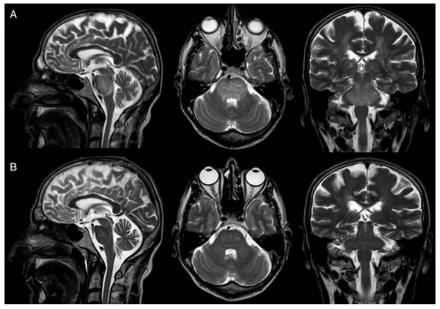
Brain MRI before and after treatment. (A) 1.5 Tesla brain MRI, before treatment. Axial, sagittal, and coronal T2-weighted images show the presence of a swollen pons with diffuse hyperintensity of the whole pons corresponding to vasogenic edema. (B) 1.5 Tesla brain MRI, 3 weeks after treatment. Axial, sagittal, and coronal T2-weighted images show disappearance of the previous hyperintensity of the whole pons due to regression of the previous edema.
